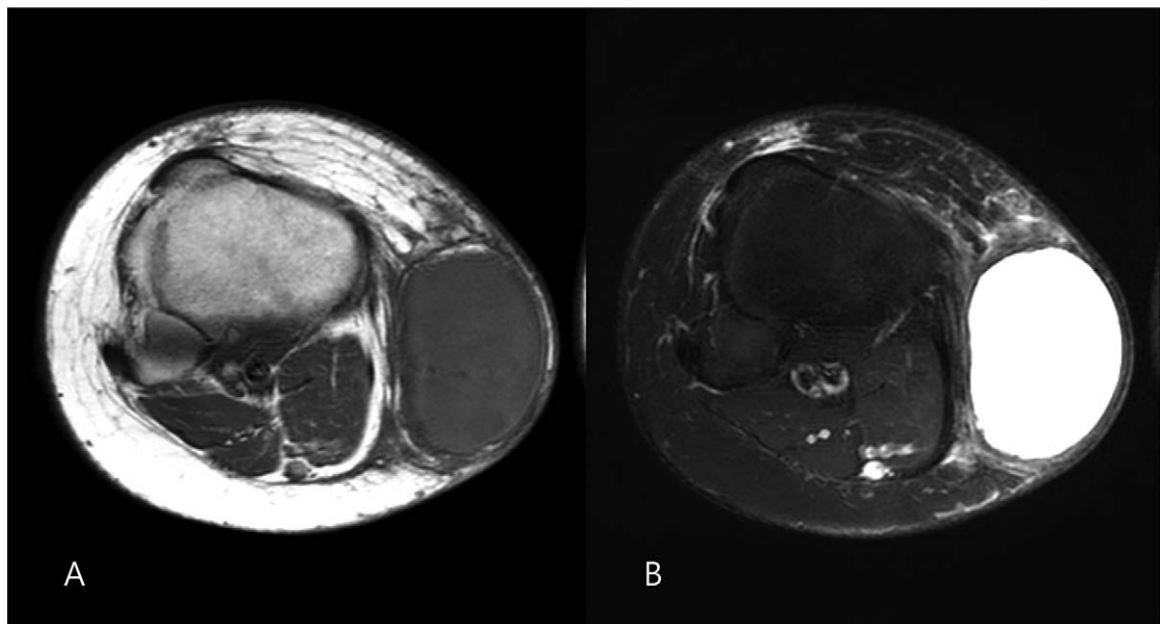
(A) An axial plane T1-weighted MRI image of low, homogeneous signal intensity, and, (B) an axial plane T2-weighted MRI image exhibiting high-level signal change. MRI = magnetic resonance image.
